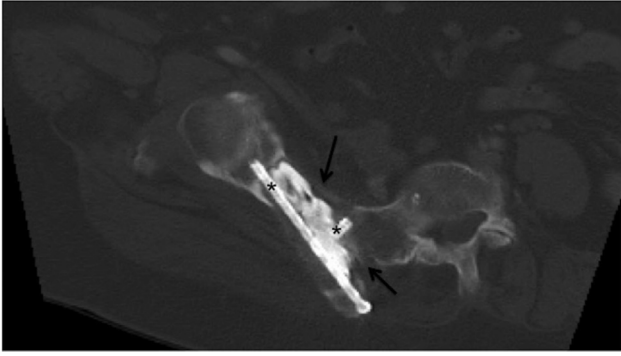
(Patient 1) Axial-oblique reformatted computed tomography image also shows the near-complete filling of the lytic cavity as well as the crossing screws (*) through the iliac mass and the sacro-iliac joint. Mass involvement of bone to the edge of the joint with areas of cortical thinning and frank disruption (arrows) on both sides of the joint are shown.
